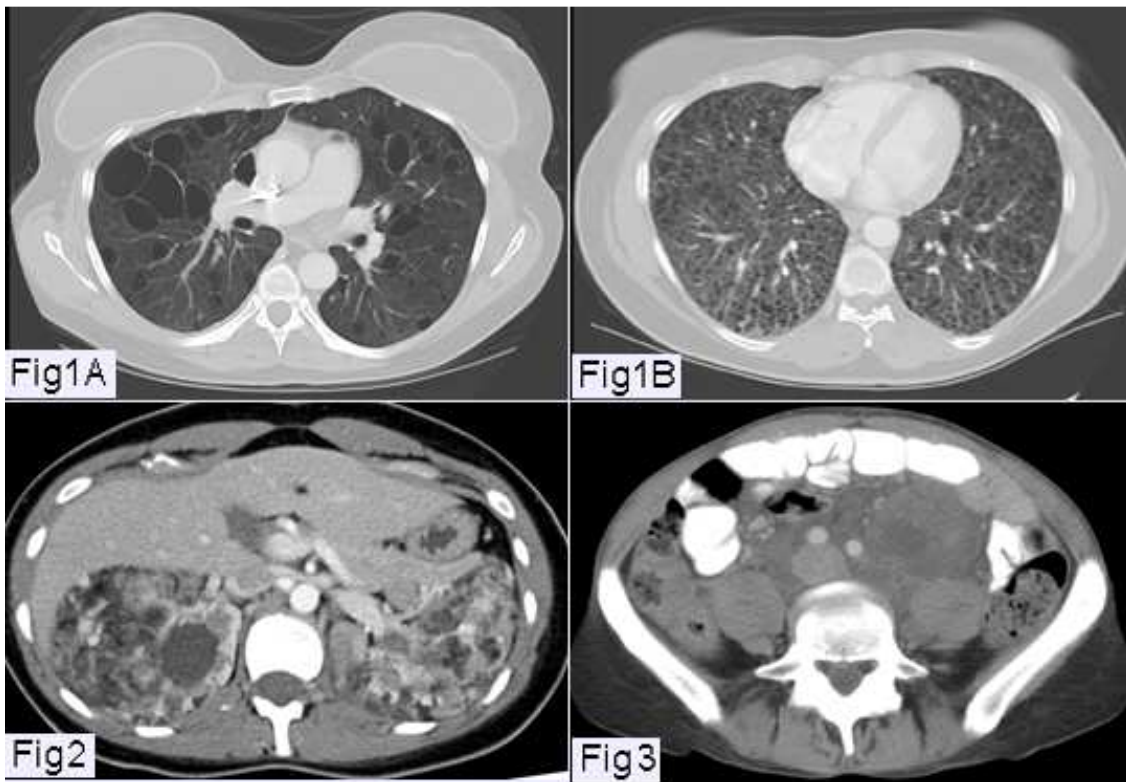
Chest CT scan of a patient with LAM (A) showing numerous thin-walled cysts distributed throughout the lungs. (B) The lung parenchyma is almost completely replaced by very small cysts.
